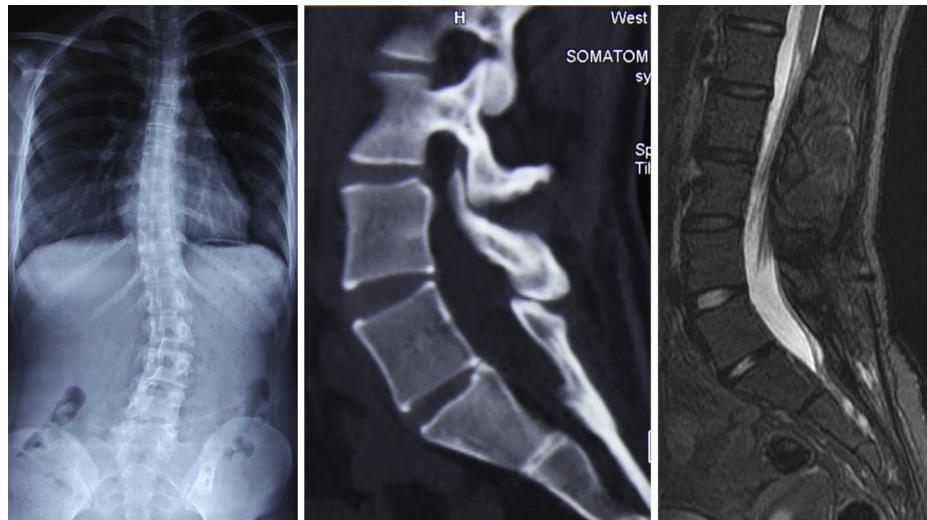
Radiographs at 6.5 years after surgery. (Left) Anterior-posterior view of total spine X-ray shows a mild primary lumbar scoliosis (Cobb 27°). (Middle) Sagittal CT scan shows a solid posterior fusion. (Right) MRI shows a repaired L5–S1 disc.
